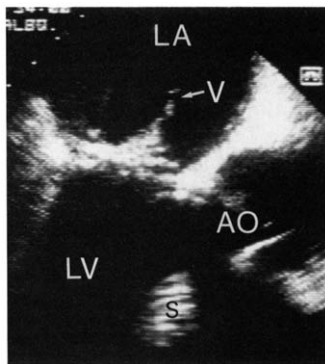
Infected mitral bioprosthesis. This systolic transesophageal view shows a mass (V) attached to the bioprosthetic sewing ring and prolapsing into the left atrium (LA). The image plane is positioned between the bioprosthetic struts, which are not shown. The distance between diagonal dots along the side of the left strut is 1 cm. Transthoracic examination of the prosthesis failed to demonstrate this mass, primarily because of acoustic shadowing from the struts and sewing ring. AO = aortic valve; LV = left ventricle; S = interventricular septum.
